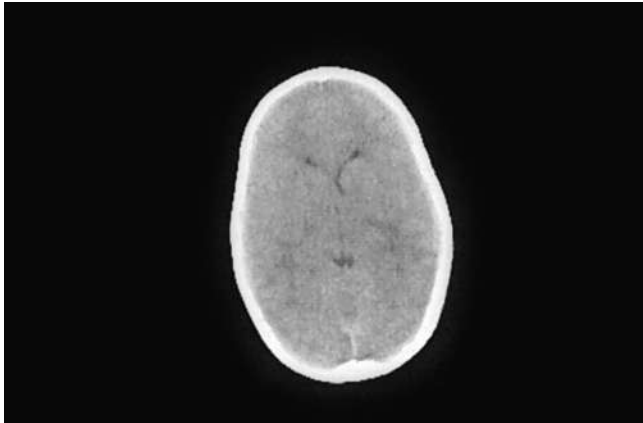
CT scan of the brain of a child with diabetic ketoacidosis complicated by cerebral oedema. There is marked swelling of the brain substance with compression of the lateral ventricles.
